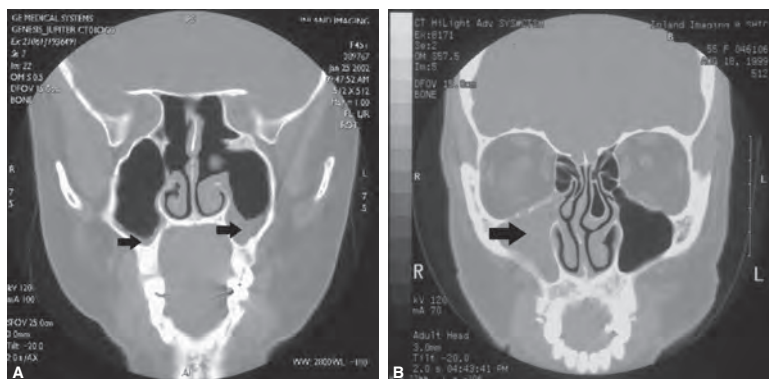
Maxillary rhinosinusitis. A, Coronal CT image of mucosal thickening and fluid accumulation in the maxillary sinuses (arrows). B, Coronal CT image of a completely obstructed right maxillary sinus (arrow).
